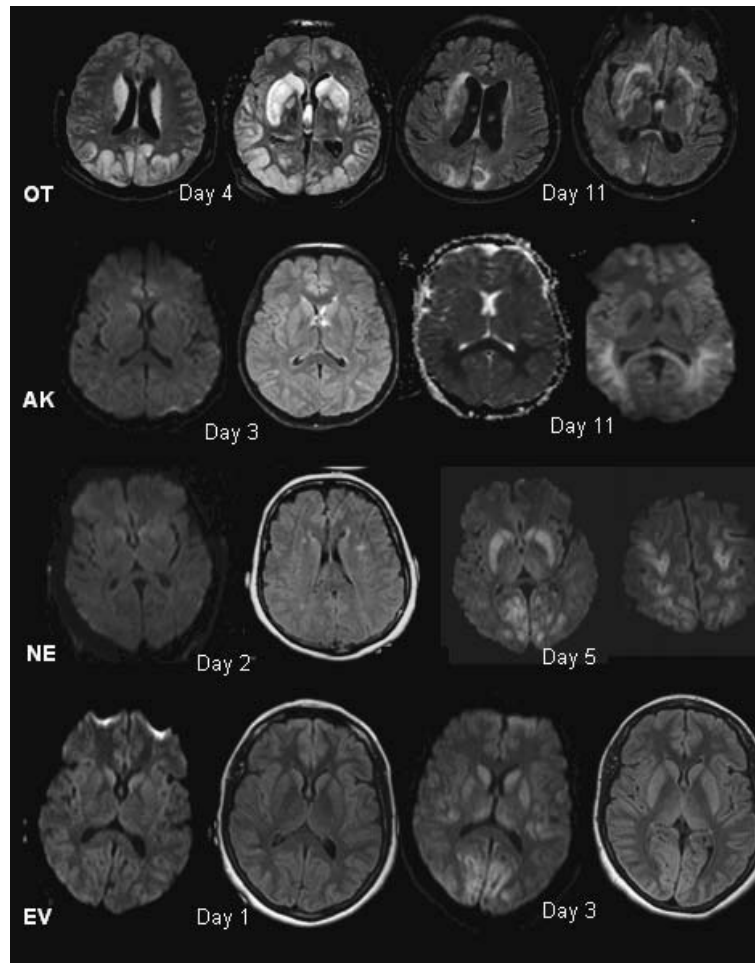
MRI lesion evolution in PRE patients with follow-up MRI.
